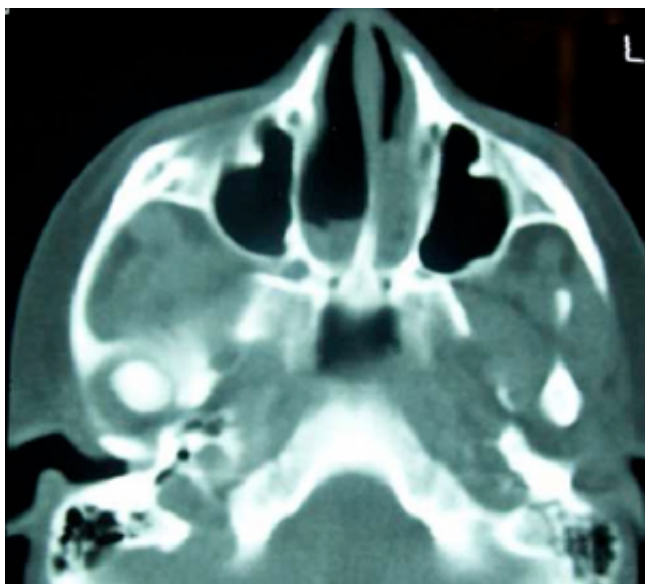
Preoperative axial paranasal sinus CT showing bilateral congenital choanal atresia.
